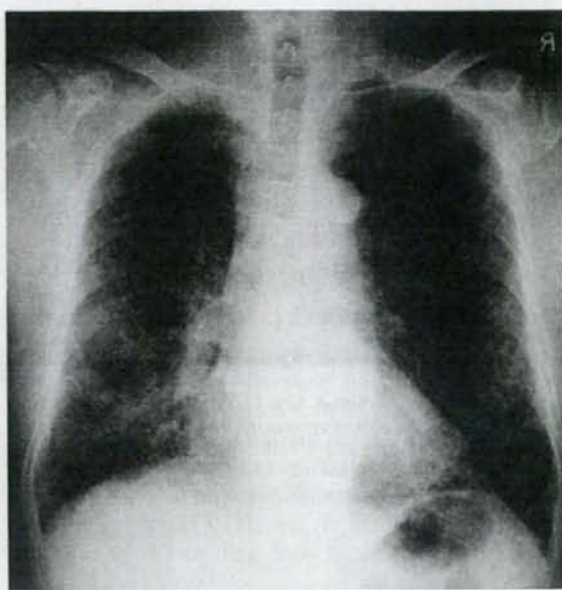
Chest X-ray taken on admission (August 22, 2003). Bilateral ground-glass opacities are apparent in the middle and lower lung fields in addition to preexisting interstitial changes.
